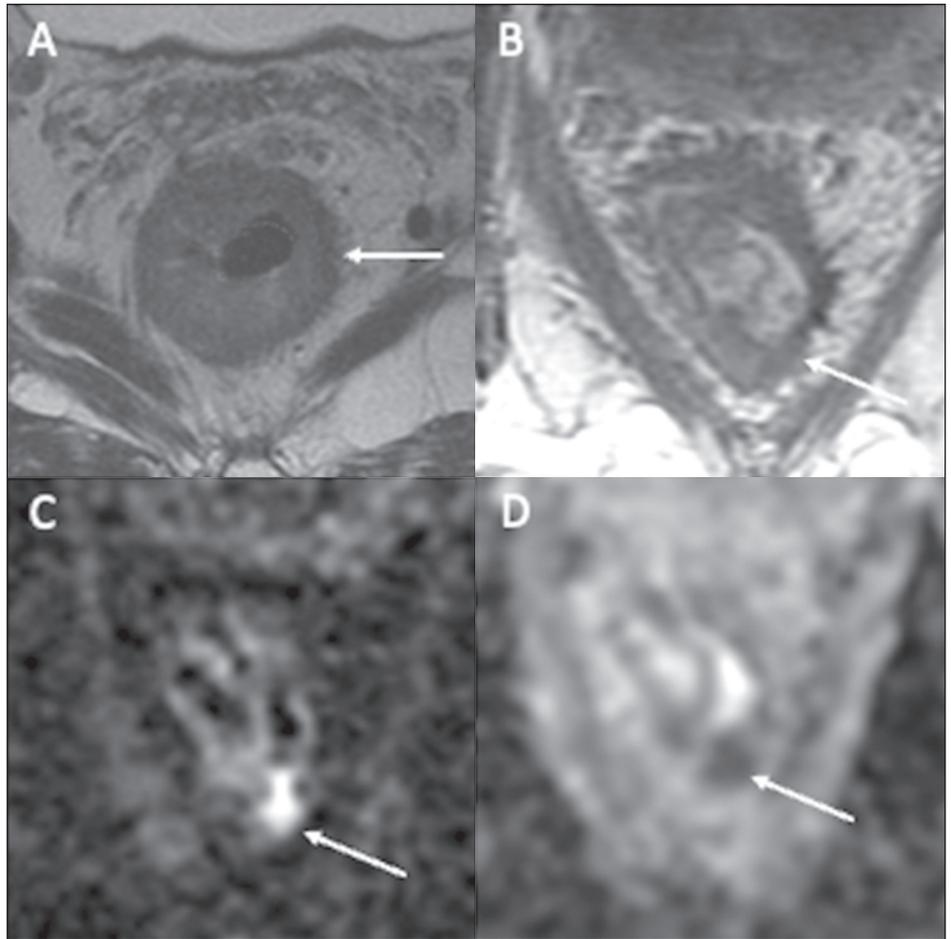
An nCR in a 63-year-old man with mid-rectal adenocarcinoma. A: Baseline axial T2WI showing a near circumferential low-rectal tumor with intermediate signal intensity (dotted line). B: Axial T2WI after the completion of neoadjuvant CRT showing new fibrosis and a residual posterior area with intermediate signal intensity on T2WI (arrow). C: Axial DWI showing high signal intensity (arrow) and axial ADC map (D) showing corresponding low signal intensity (arrow), suspicious for a small amount of viable tumor within the fibrotic tumor bed.
